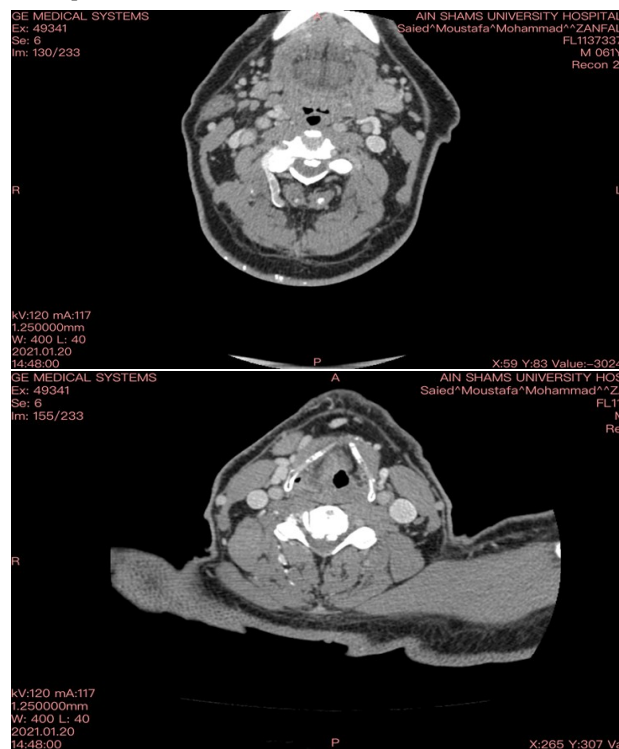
Case 1: A 53-year-old male presented with hoarseness of voice, cough, and difficulty in swallowing. CT scan showed thyroid cartilage invasion, involvement of the aryepiglottic fold with extra-laryngeal spread.
